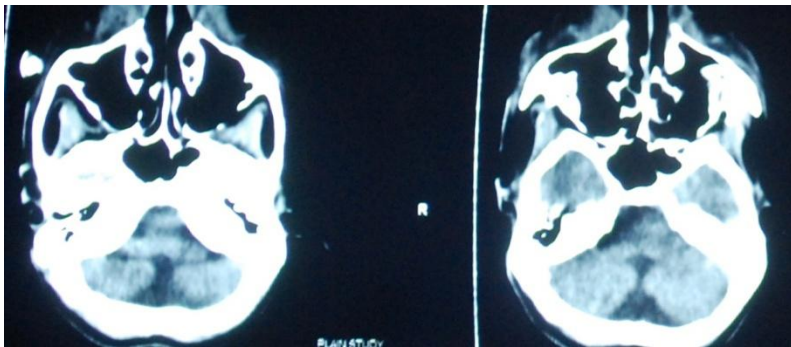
Brain atrophic changes in CT scans
